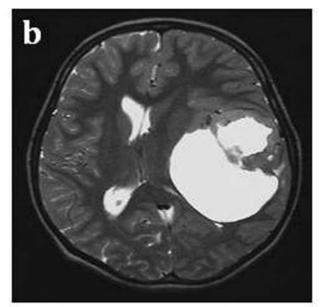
Preoperative MRI showing: a) T1-weighted imaging, b) T2-weighted imaging, and c) T1-weighted imaging with contrast enhancement.
